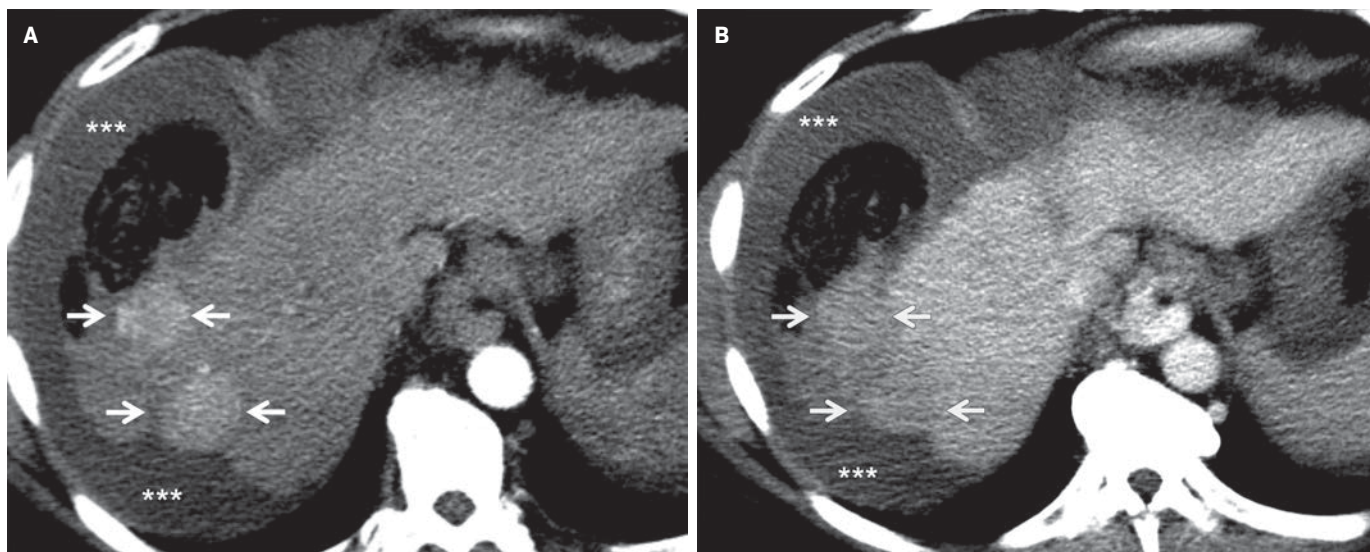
(A) Axial contrast-enhanced CT through the upper abdomen in a patient with two right hepatic-lobe, arterially enhancing, hepatocellular carcinomas (white arrows) with washout in the (B) portal venous phase (white arrows), tumoral bleeding, and perihepatic hematoma (A, B, *)
